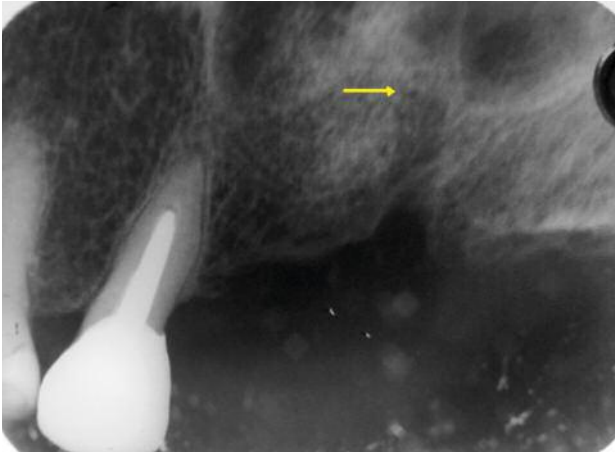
X-ray image to confirm the cutting depth (2.5 mm \varnothing) of the implant receptor site at 10 mm (arrow). Partial replacement of the bone substitute material with receptor bone is obvious.
